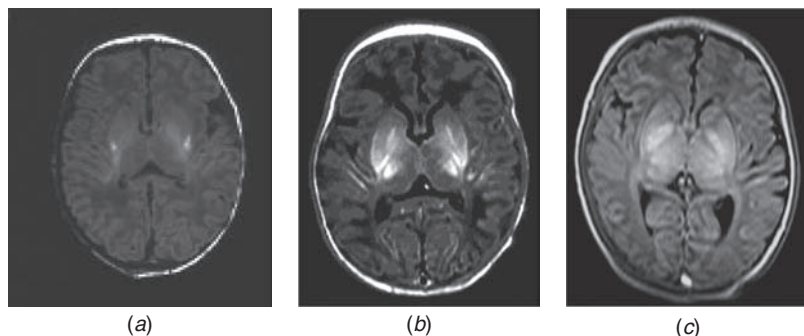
T1-weighted images in three different term-born infants with hypoxic-ischemic encephalopathy showing (a) mild, (b) moderate, and (c) severe abnormal signal intensity within the basal ganglia and thalami.
